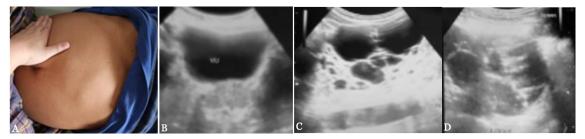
Physical observation of abdomen (A) and urology ultrasound (B-D) of the patient. The clinical shows enlarged, tense, and rigid abdomen (A) and urology ultrasound showed bilateral kidney enlargement (A) with multiple cysts (B) and calcifications (C).
